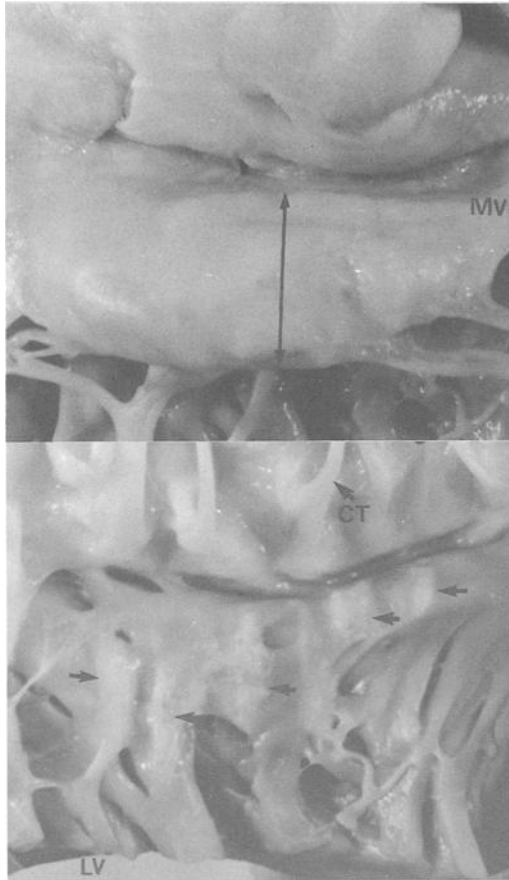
Close-up of the floppy mitral valve (MV) shown in Fig. 1, and demonstrating leaflet “hooding” (long arrow, upper) and left ventricular (LV) endocardial friction lesions (small arrows, lower) underlying the chordae tendineae (CT).
